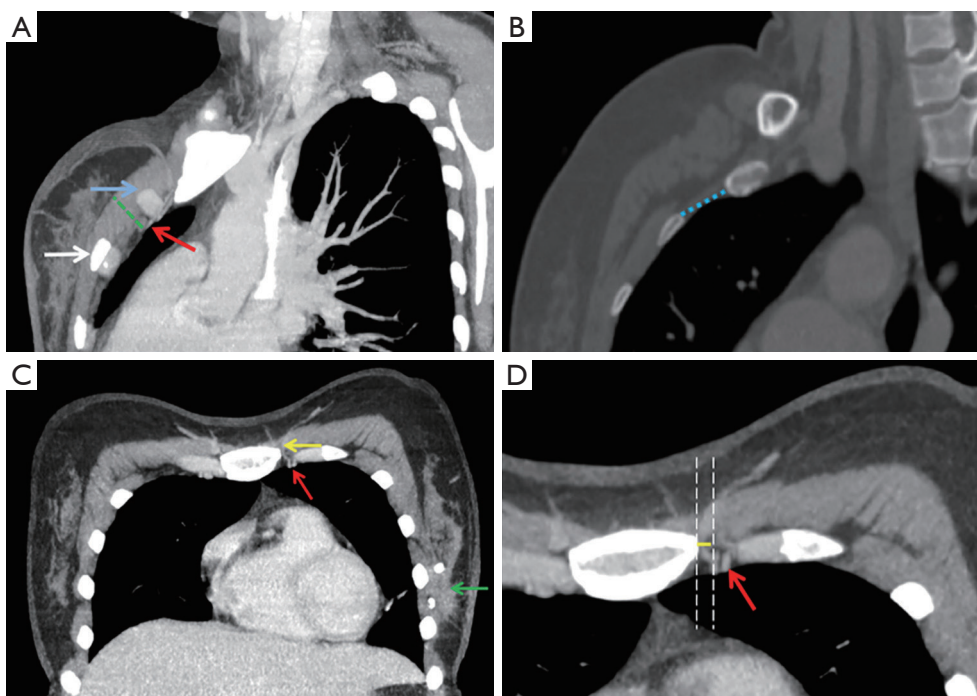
Measurement of intercostal space. (A,B) The internal mammary vessels were marked in sagittal reconstructed images (red arrow), parallel to the position recorded in the operation. The width of ICS (blue line) was measured between the costal cartilage (blue arrow) and the depth (green line) was measured from the surface of the pectoralis major muscle to the IMVs; (C,D) distance (yellow line) was measured between the parasternal line and IMVs in transverse reconstruction images. White arrow: the rib; green arrow: locating clips in breast tumor; yellow arrow: the sternum; red arrows in (C,D): internal mammary vessel. ICS, intercostal space; IMV, internal mammary vessel.
